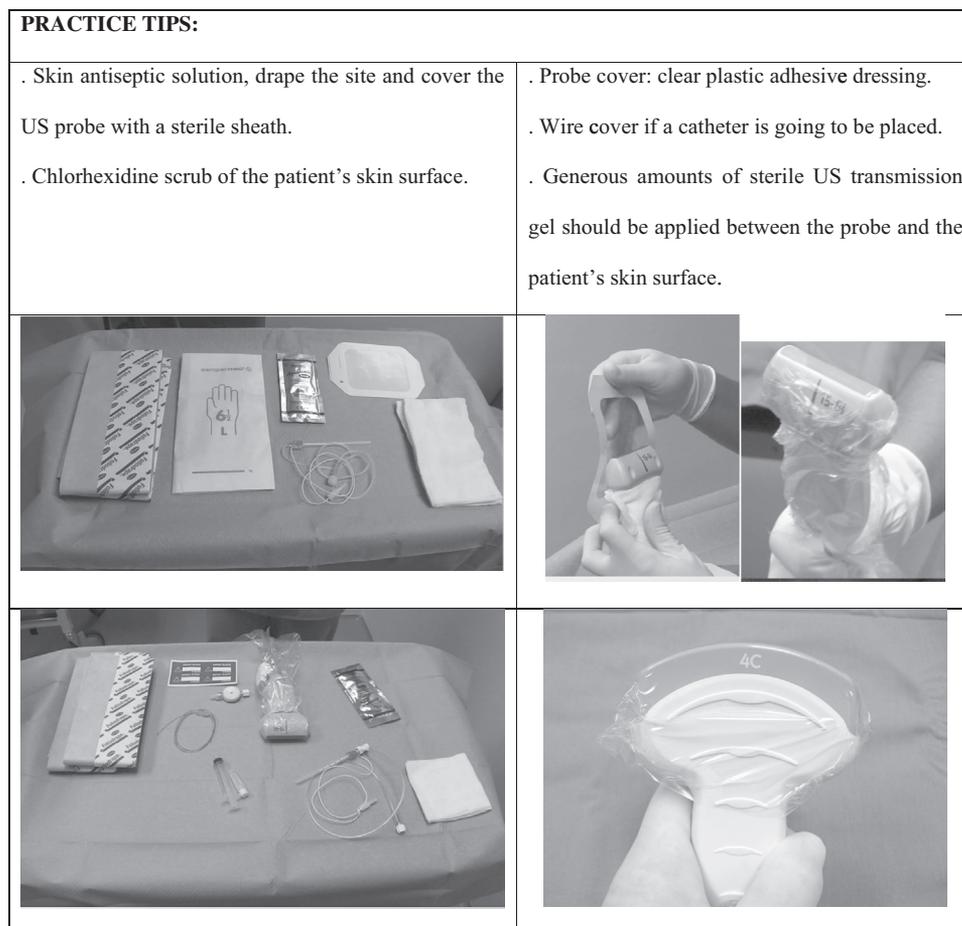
Practice tips for an aseptic technique for ultrasound-guided interventions.
